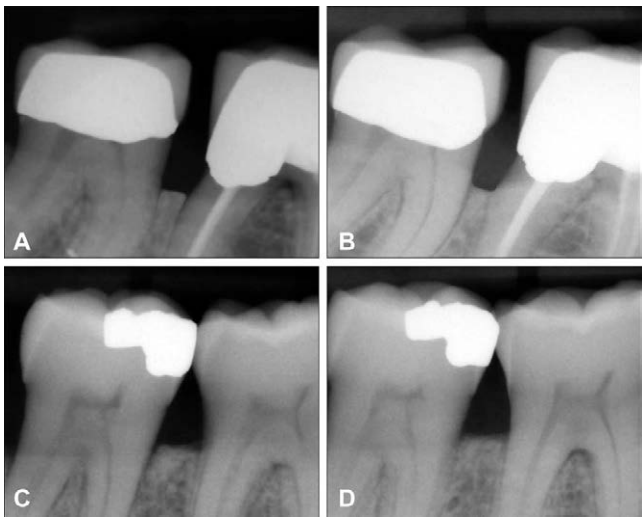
Interproximal radiographic anatomy. Top panel shows molar-molar open interproximal contact and bone loss on #30 distal between baseline (A) and two years of periodontal maintenance (B). Bottom panel shows molar-molar contact and minimal molar interproximal bone change between baseline (C) and two years of periodontal maintenance (D).
